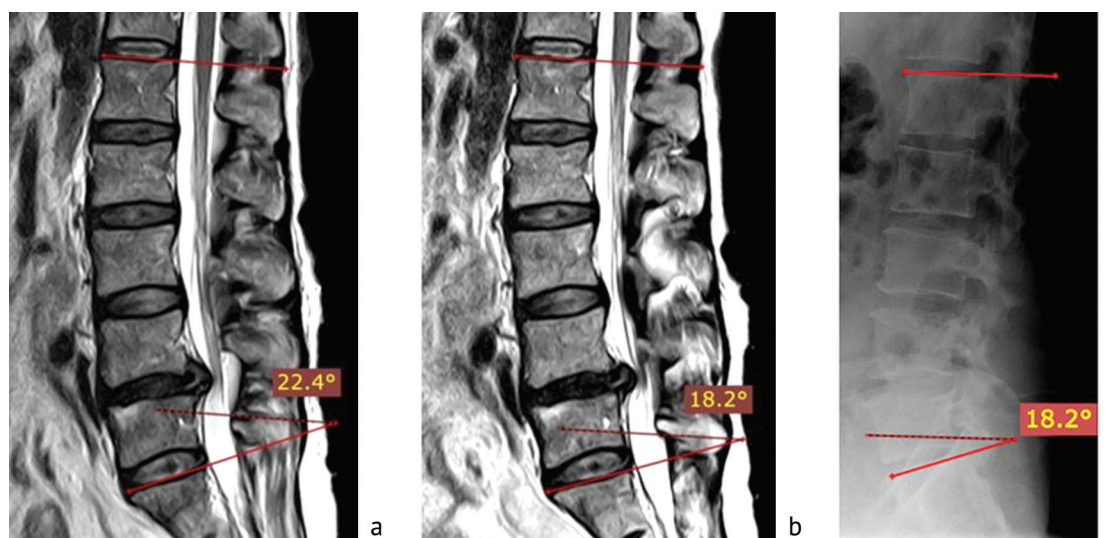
MRI scans (T2-WI) of the lumbar spine in the sagittal plane: *a* – in the supine position, *b* – in dosed axial load; *c* – lateral radiograph of the lumbar spine. The magnitude of lordosis detected by MRI with functional load and radiography is comparable
